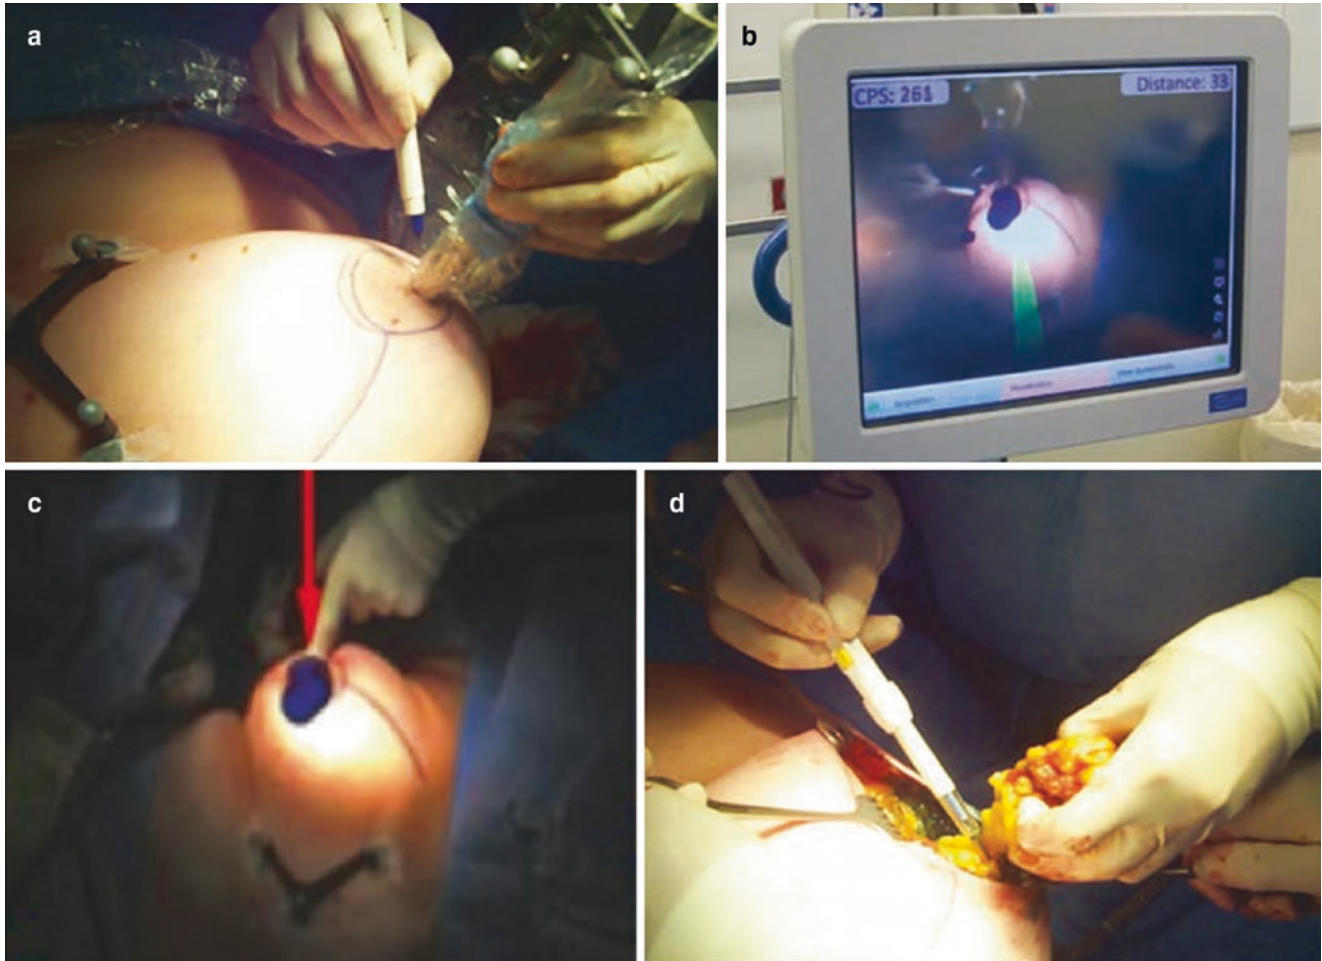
Free-hand SPECT system used for radioguided occult lesion localization (ROLL) in a patient with non-palpable breast cancer. (a) Surgical approach for ROLL; the tracking device positioned on the patient's body is visible on the left. (b, c) Overlay of freehand SPECT
